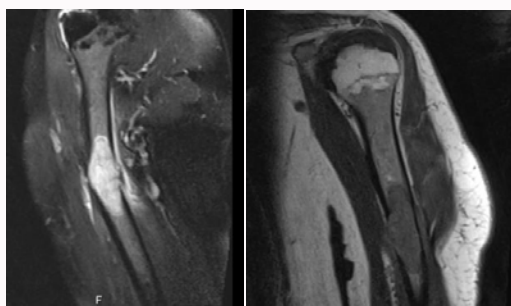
The patient has MRI T1 and T2 lesion defects.
